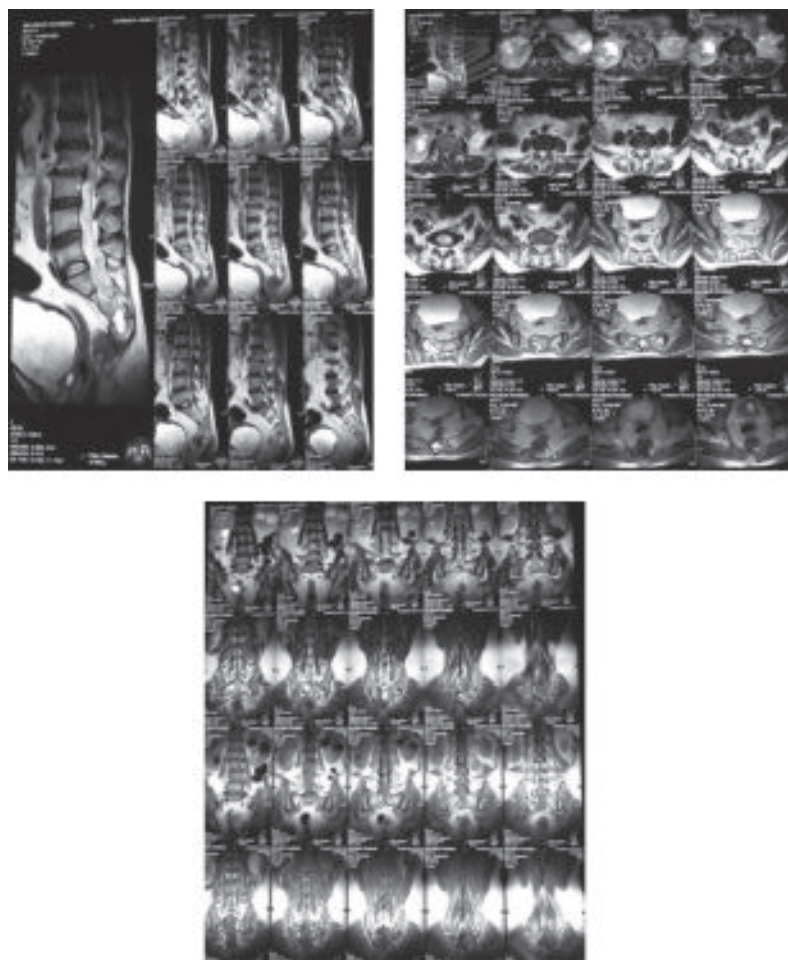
Preoperative MRI of Lumbosacral spine with different views showing significant compression over thecal sac extending from L2 to sacral region by huge collection of pus extradurally and posteriorly.
